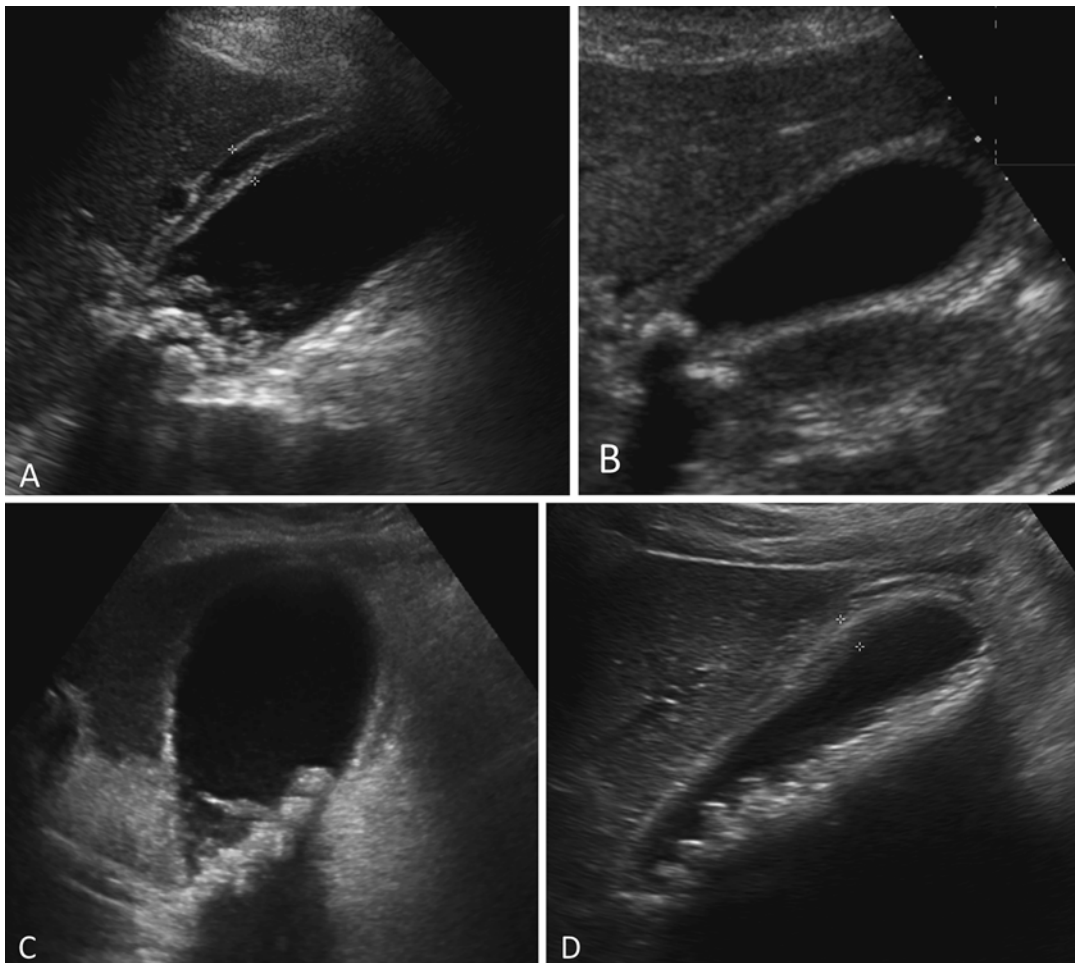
Gray-scale ultrasound of the gallbladder with related abnormal findings. (a) Cholelithiasis and gallbladder wall thickening up to 8 mm. (b) Gallstone lodged in the gallbladder neck with associated wall thickening. (c)
